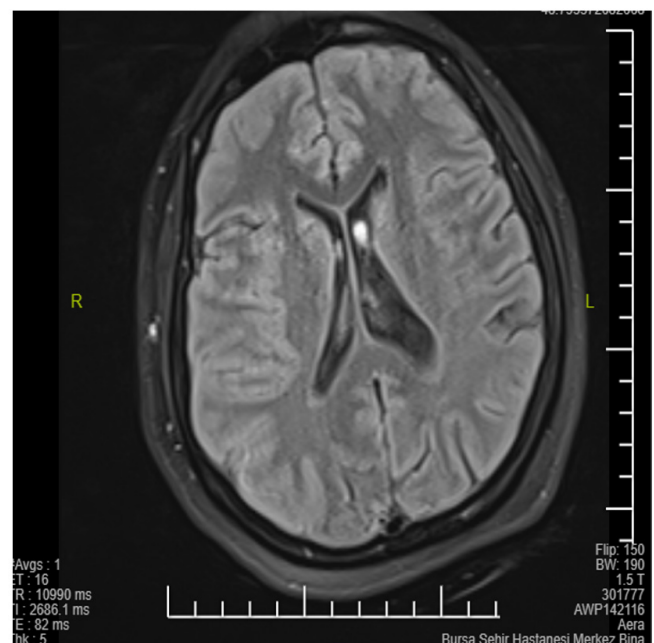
First magnetic resonance imaging with fluid-attenuated inversion recovery sequence
